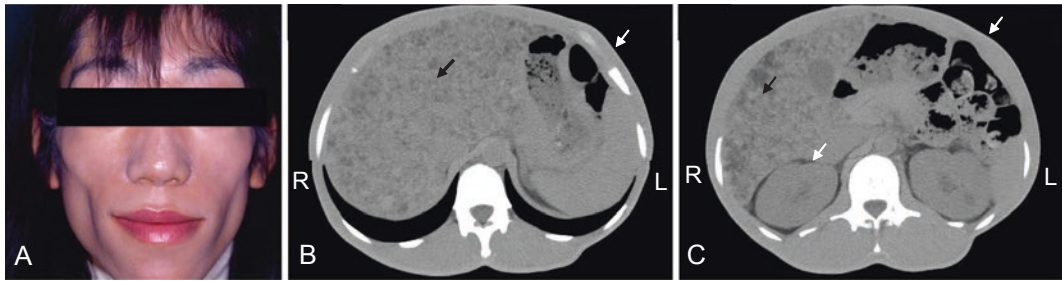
The presented case with congenital lipoatrophy. (a) Photograph of the patient. (b) and (c) Computed tomography of the abdomen. Prominent fatty liver is noted, and both subdermal and abdominal adipose tissues
